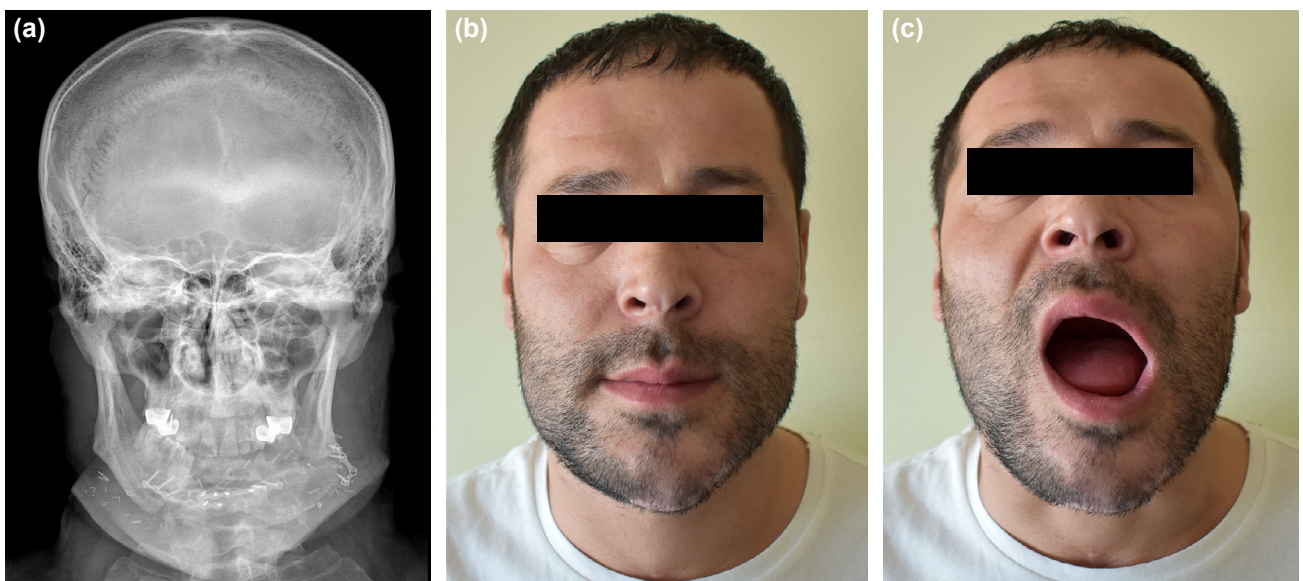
(a-c) Postoperative radiograph and view of the patient. The iliac crest free flap was properly incorporated to the defect. The occlusion and mouth opening was very good.
